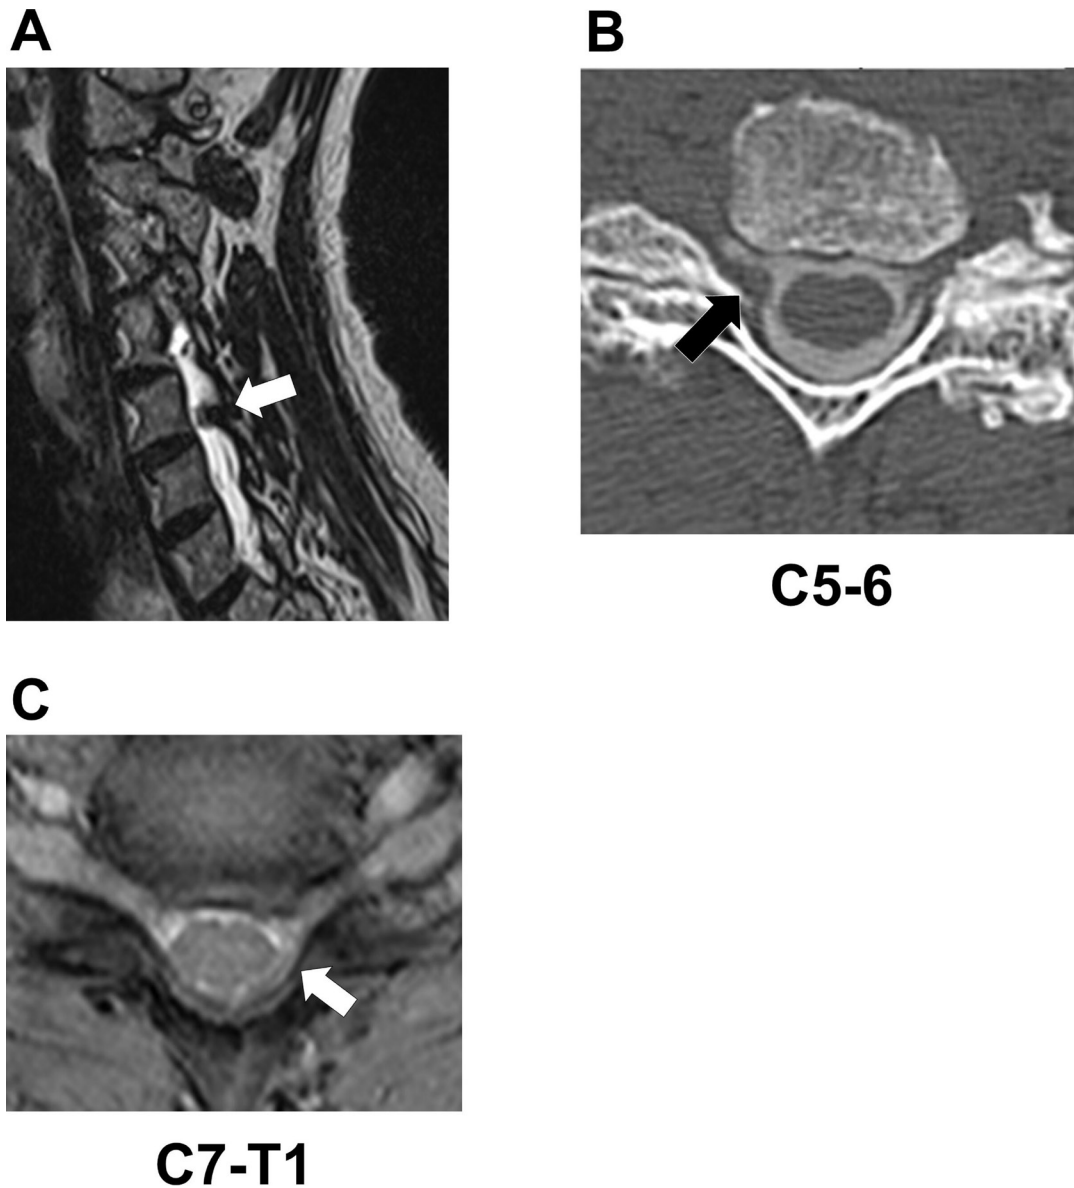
Magnetic resonance imaging (MRI) and computed tomography (CT) images prior to the surgery in Case 3 and 4. (A) T2-weighted sagittal MRI image of Case 3. The white arrow points to the lesion at C5-C6. (B) C5-6 axial CT myelogram image of Case 3. The black arrow points to the loss of contrast as a result of the lesion at the border between the intervertebral foramen and spinal canal on the right side. (C) T2-weighted axial MRI image of Case 4. The white arrow points to the lesion from the spinal canal to the intervertebral foramen at the C7-T1 on the left side.
